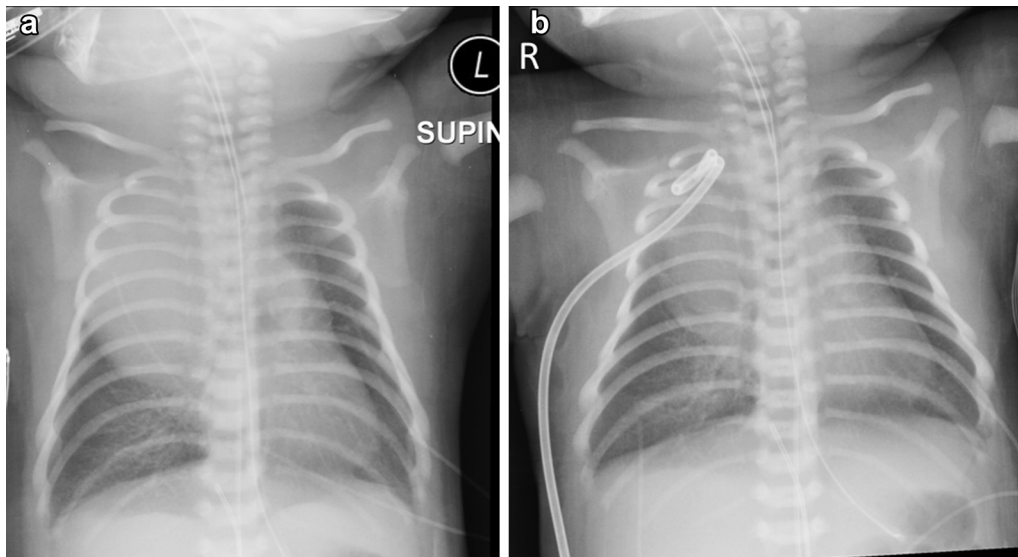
(a) Radiopaque opacity occupying the right upper hemithorax with resulting right lower lobe atelectasis. A nasogastric tube and an endotracheal tube are in place. (b) Post procedural chest radiograph demonstrates a pigtail catheter in the right upper chest mass, which has decreased in size compared to the pre-procedure study. A nasogastric tube and an endotracheal tube are in place.
